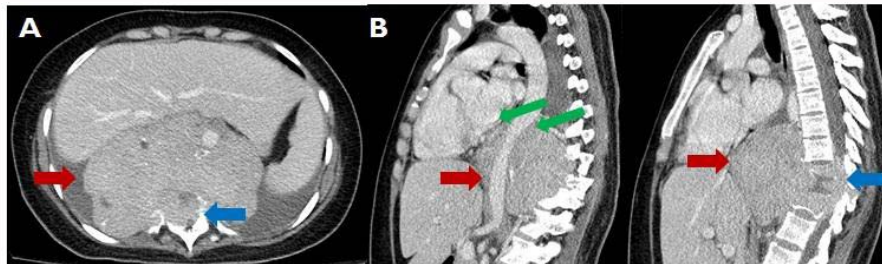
The Axial A and Sagittal B, CT scan images demonstrate large heterogeneous enhancing midline mass with areas of necrosis crossing midline in the posterior mediastinum (red arrow) measuring approximately 14 cm × 8 cm × 10.0 cm, encasing the descending thoracic aorta and causing anterior displacement and mass effect on the heart (green arrow). There destruction of the ninth and tenth and thoracic vertebra extending into the spinal canal with encasement and compression of the cord where (blue arrow).
